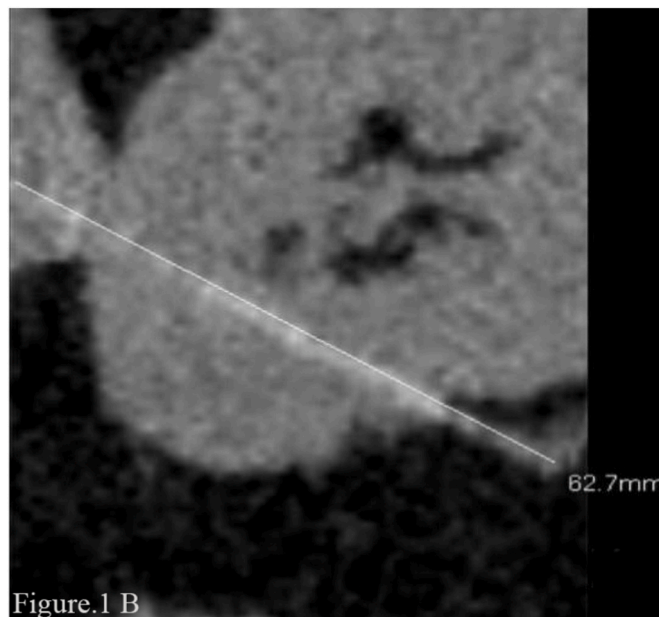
A: In the sagittal plane of abdominal CT scanning images, the foreign body passes through the right lower renal pole (shown by the arrow). B: CT reconstruction image of foreign body. C: Gastroscope picture of the patient.
